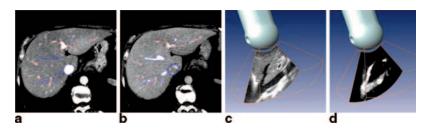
A CTA is shown in (a) and (b). a Portal venous phase, and b late venous phase. c Shows a B-mode ultrasound of the liver, while d shows a power Doppler image of the same: lice. (From [14])
